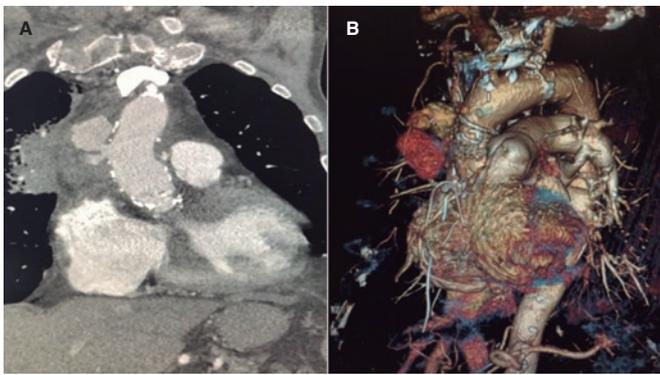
Coronary computed tomography angiography with contrast. Coronal view (A) and 3D reconstruction (B). Extensive atheromatous disease in the ascending aorta with diffuse calcification. Solution of continuity in the ascending aorta lateral wall with contrast extravasation contained by the tunica adventitia or surrounding tissues making up a partially thrombosed narrow-necked saccular pseudoaneurysm.
